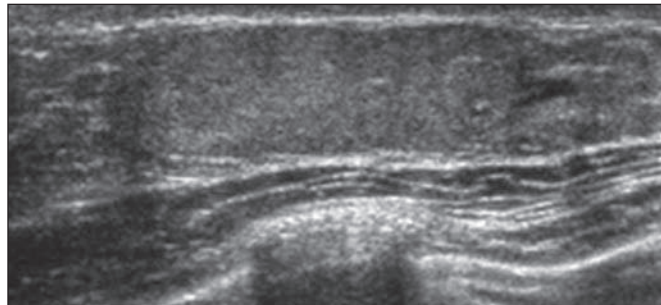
17-year-old girl with palpable breast mass 1 year postpartum. Sonogram shows well-defined mildly hyperechoic 2.6-cm mass with through-transmission. Excisional biopsy revealed lactating adenoma.
